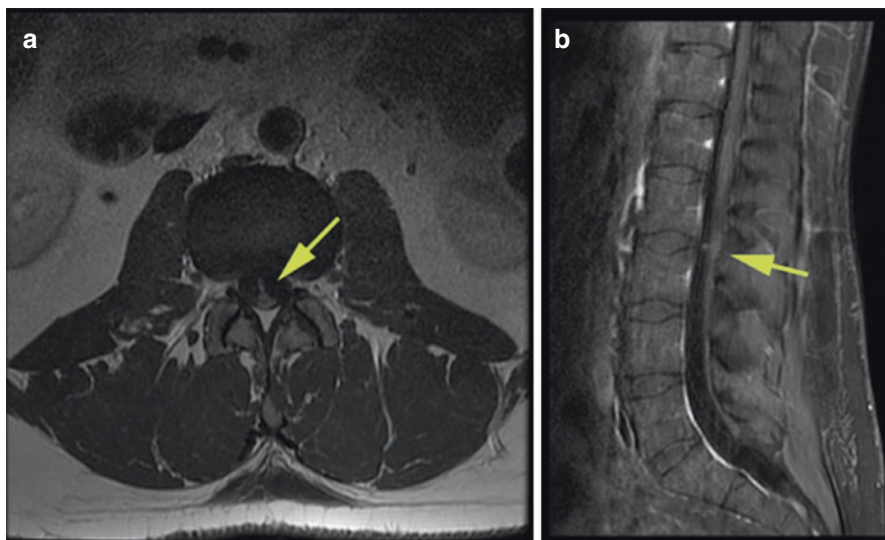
(a, b) Axial and sagittal T1-weighted MRI with contrast depicting intradural extramedullary cauda equina schwannoma
